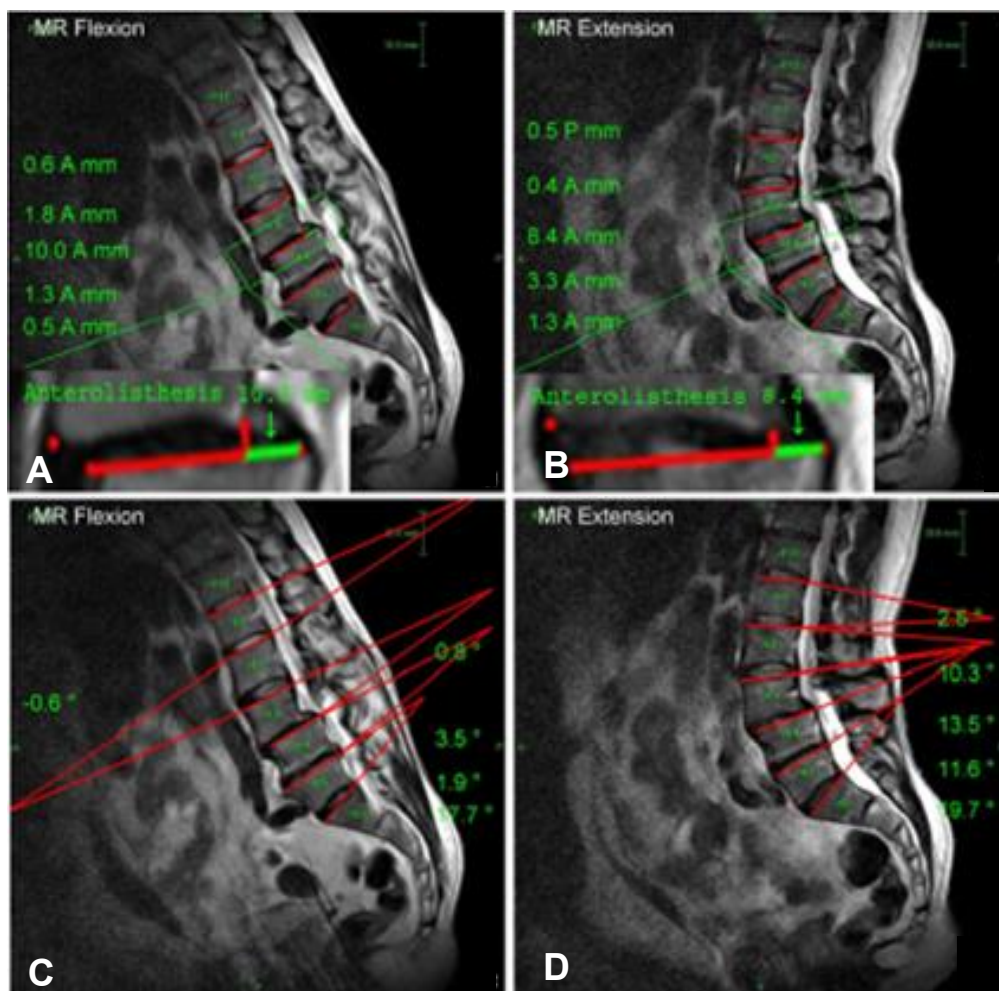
Figure and content for figure legend adapted from Fujii, R., Sakaura, H., Mukai, Y., Hosono, N., Ishii, T., Iwasaki, M., Yoshikawa, H., Sugamoto, K., 2007. Kinematics of the lumbar spine in trunk rotation: in vivo three-dimensional analysis using magnetic resonance imaging. *European Spine Journal* 16, 1867-1874; Cholewicki, J., McGill, S., Wells, R., Vernon, H., 1991. Method for measuring vertebral kinematics from videofluoroscopy. *Clinical Biomechanics* 6, 73-78; Frobin, W., Brinckmann, P., Leivseth, G., Biggemann, M., Reikeras, O., 1996. Precision measurement of segmental motion from flexion-extension radiographs of the lumbar spine. *Clinical Biomechanics* 11 (8), 457-465. Used with permission.
